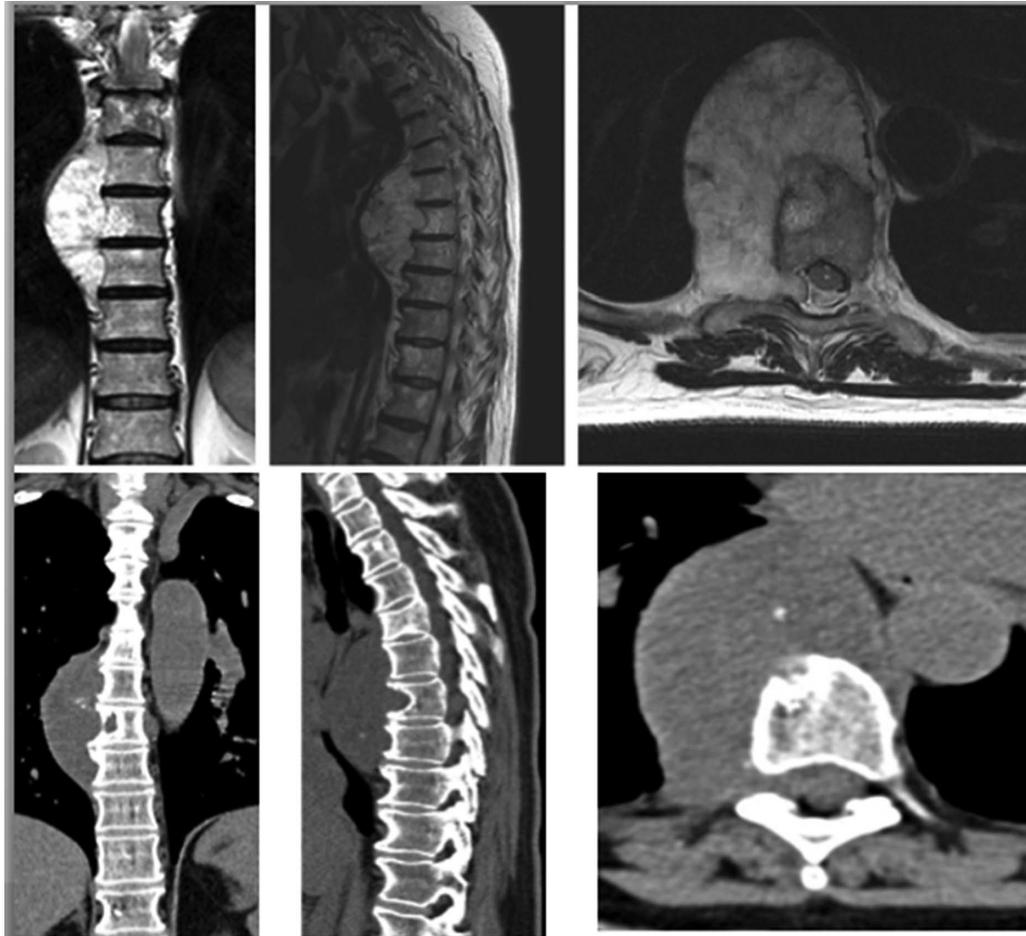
Coronal, sagittal, and axial MRI (top L to R) and CT (bottom L to R) showing chordoma extending from T5–T9. MRI indicates magnetic resonance images; CT, computed tomography.
